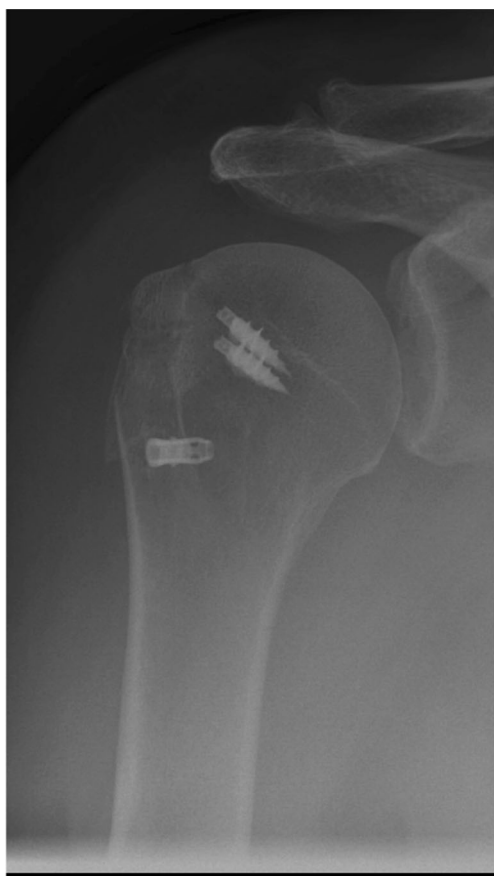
Radiograph of post-operative tuberosity fixation
